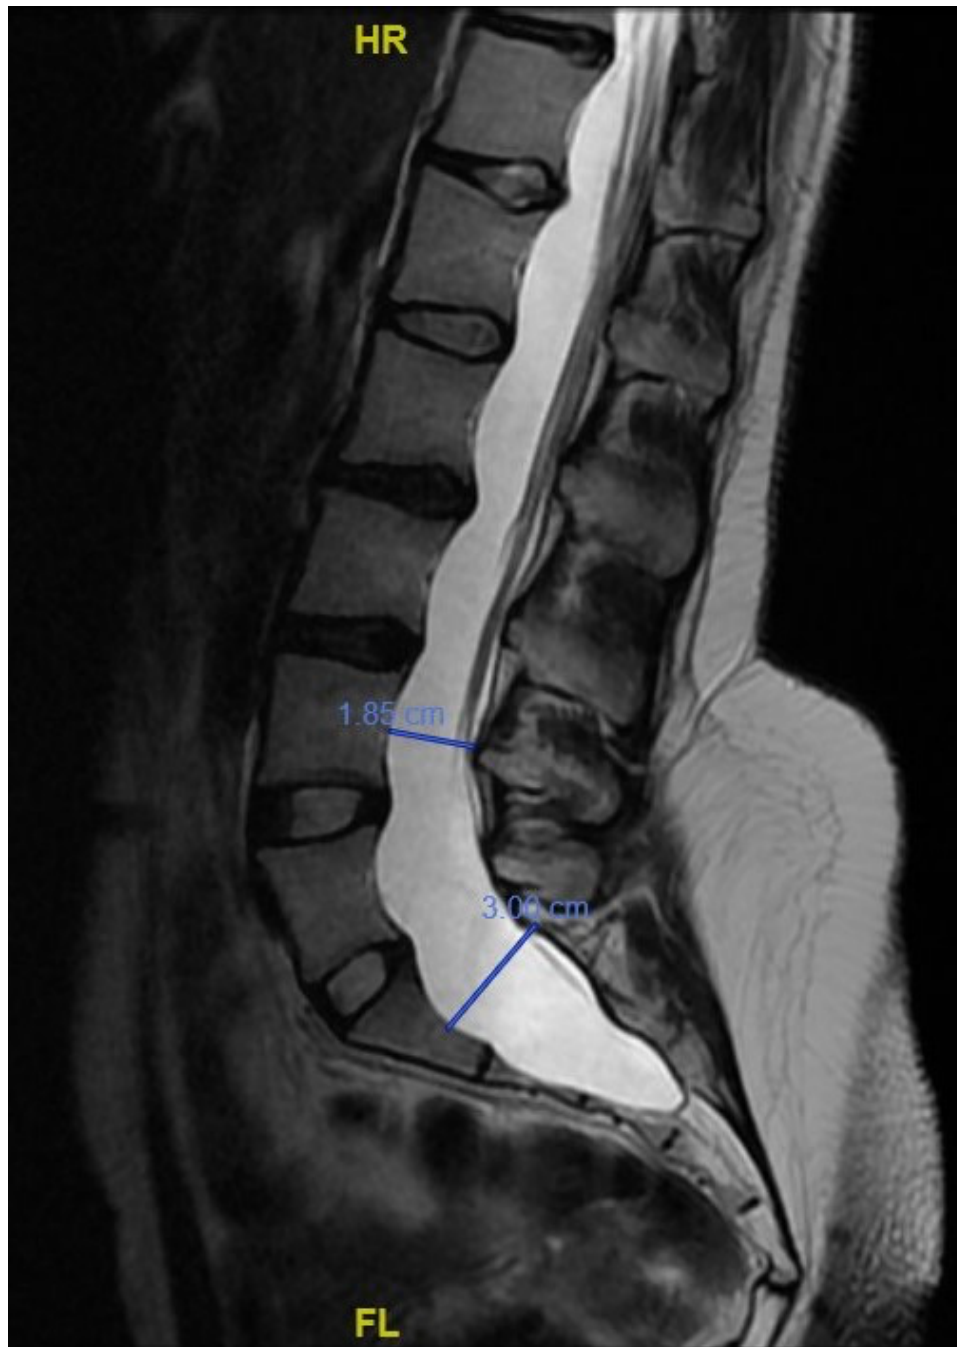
Sagittal T2-weighted lumbar MRI demonstrates cystic enlargement of the dural sac extending from the lower thoracic/lumbar levels toward the sacral region. The dural sac measured 30 mm at S1 and 18.5 mm at L4, with an S1/L4 ratio of 1.62.
